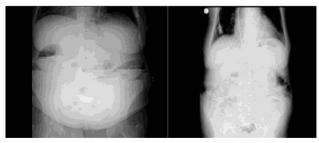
Patient's Erect Plain Abdominal Radiographs At Admission and Post-Discharge
